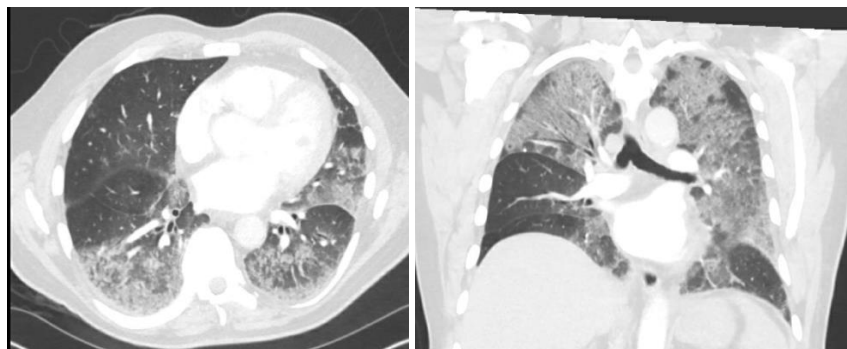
CT of the Chest, axial and coronal view with worsening bilateral ground glass opacities as compared to admission.
